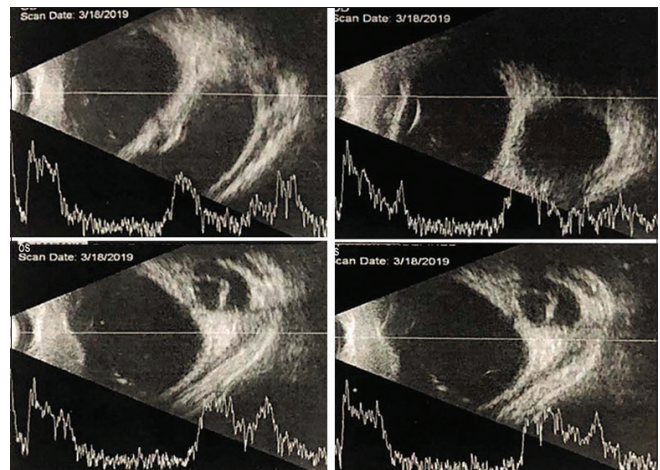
Ultrasound B-scan of both eyes showing abnormal optic nerve head with a retrobulbar hypoechoic lesion communicating with the optic nerve head
